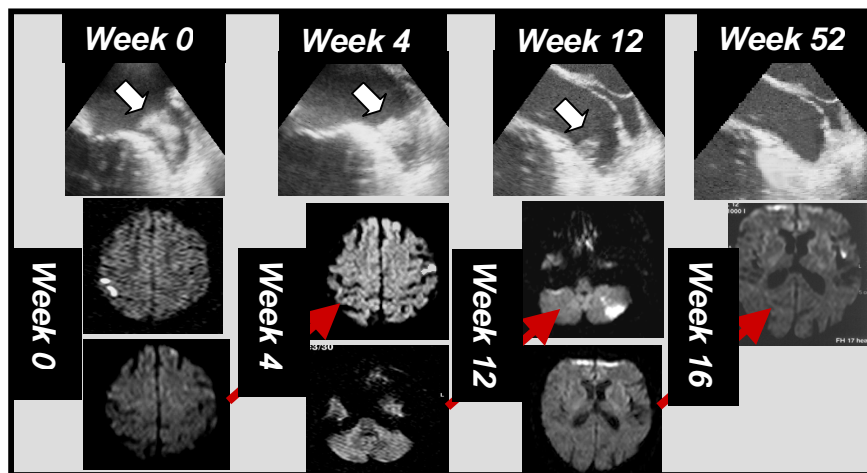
Thrombus in the LA appendage (white arrows) resolving under continuous anticoagulation from week 0 to week 52 detected by TEE (upper row), associated with multiple cerebral infarcts as assessed by serial DWI exams (middle und lower row).
